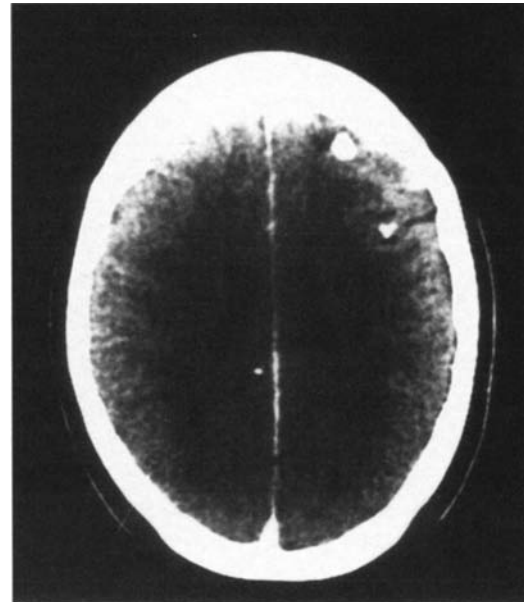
Axial CT with intravenous contrast shows multiple inactive parenchymatous calcifications in a 49-year-old woman, 6 months after treatment of cysticercosis with praziquantel.
